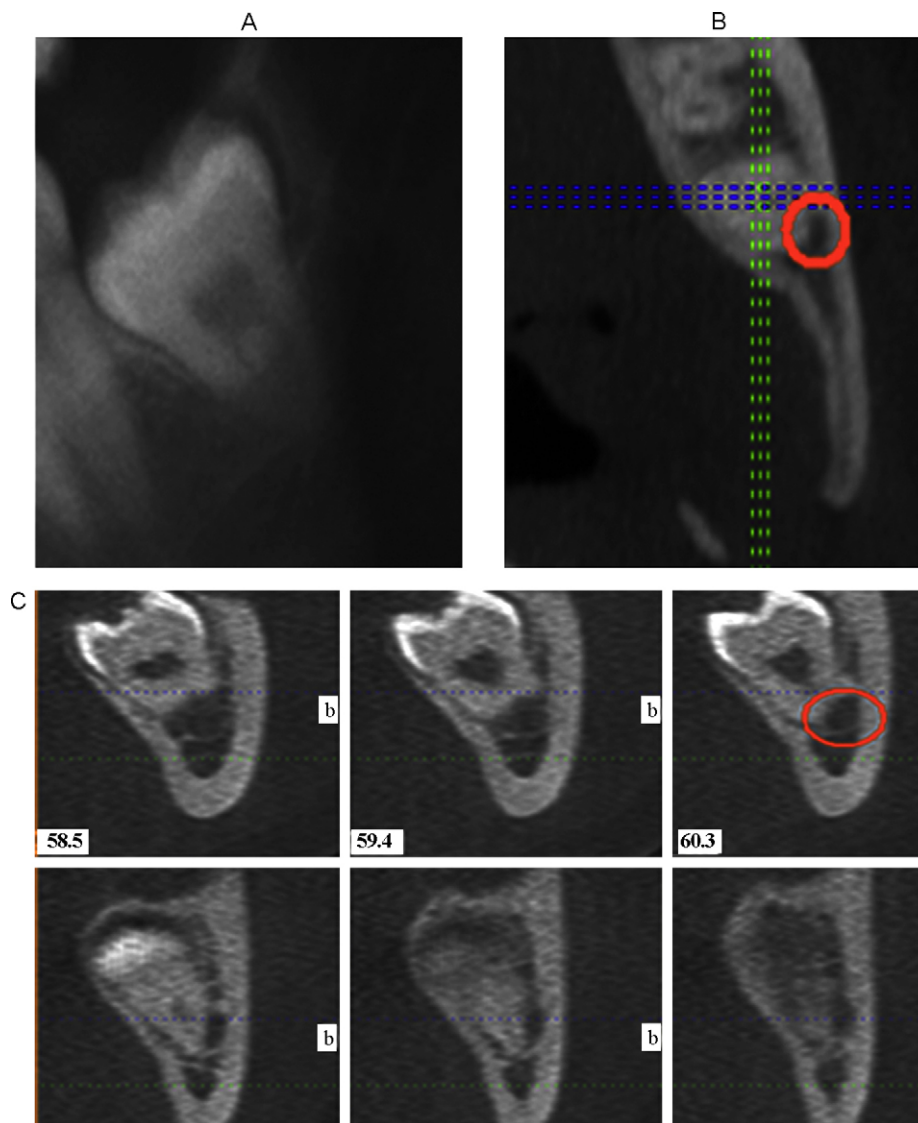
Panoramic radiograph showing darkening of the roots and interruption of the white lines of the mandibular canal (A). Transverse (B) and coronal (C) CBCT images show a flattened mandibular canal between the root and buccal cortex with disappearance of the cortical layer of the mandibular canal. The IAN was exposed during removal as anticipated from the CBCT images.
